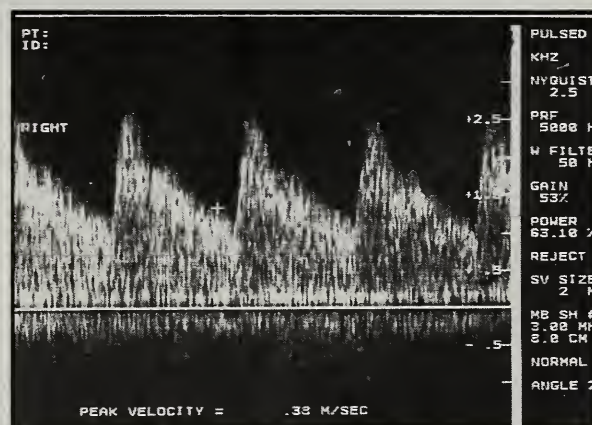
Doppler spectral analysis.
